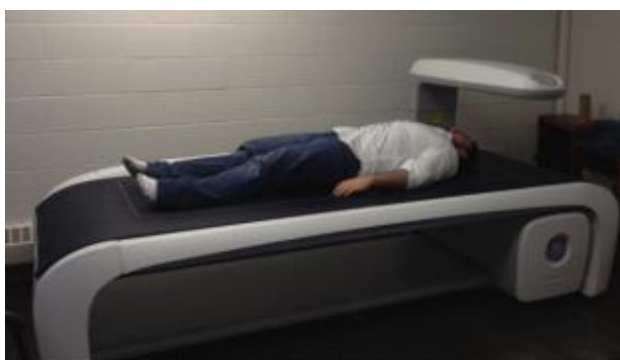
Lunar iDXA™ (Dual Energy X-Ray Absorptiometry (DXA), GE Healthcare™, USA)
